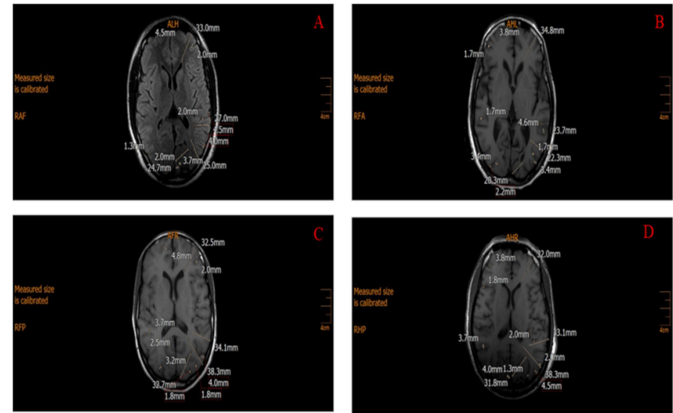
Prototype of measured MRI brain images – Coronal sections (National Hospital Abuja, 2023).
